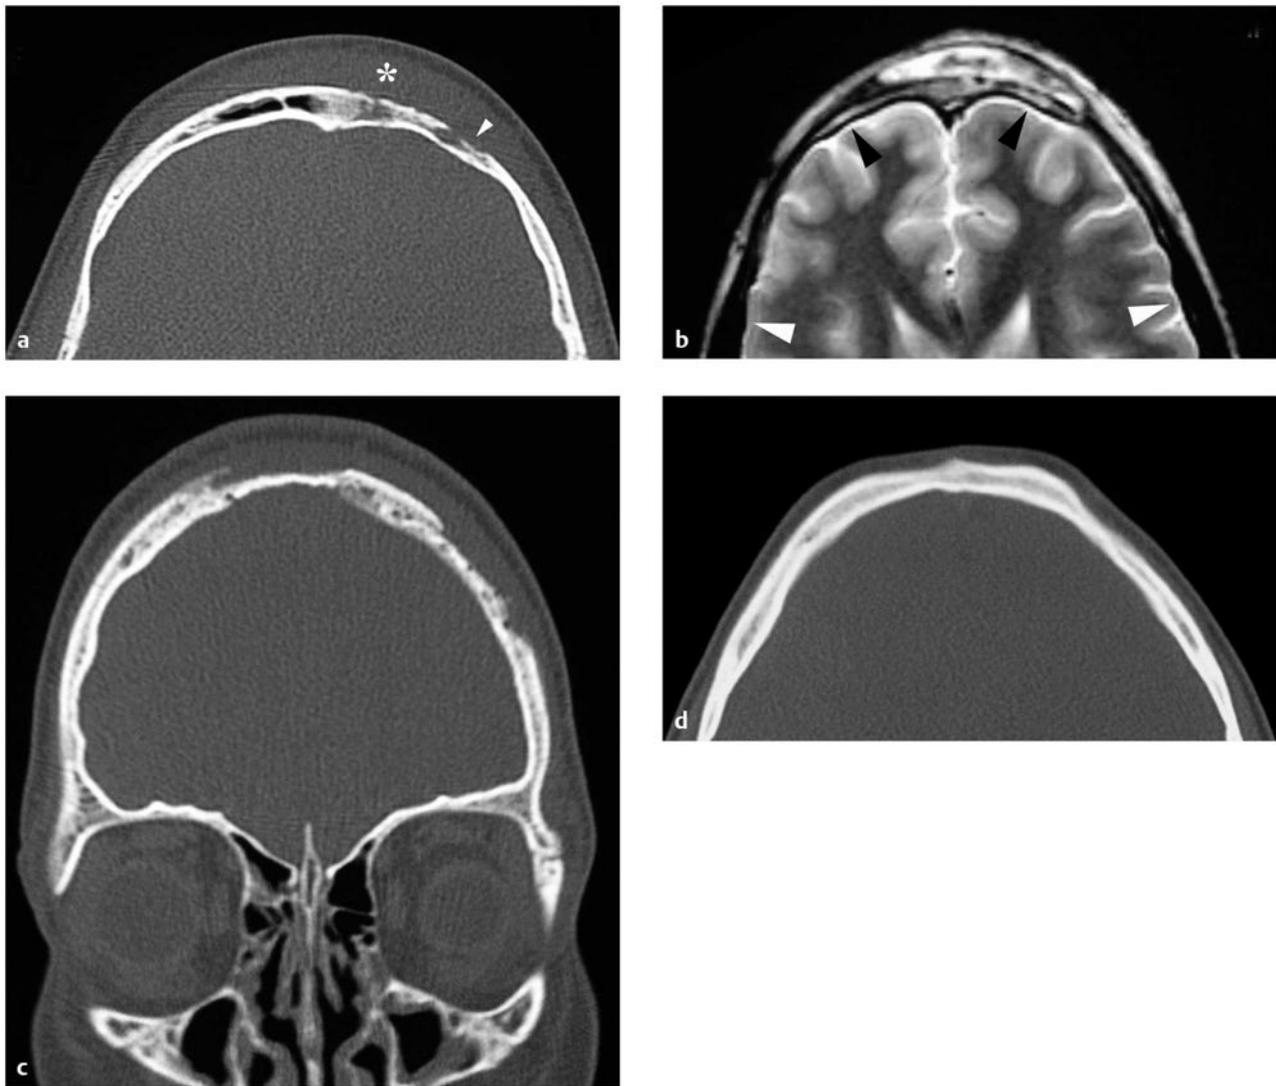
(a) A male teenager came to attention with headache, fever, and extensive swelling of his forehead and scalp. This computed tomographic (CT) scan performed early in his course shows a large subperiosteal abscess (*white asterisk*) and osteomyelitis of the frontal bone with extensive erosive changes (*white arrowhead*). (b) This axial, T2-weighted MR imaging sequence shows high signal intensity, reflecting marrow edema in the involved frontal bone (*black arrowheads*), in comparison with the relatively uninvolved parietal bones (*white arrowheads*). There was no epidural abscess in this case. (c) Despite sinus drainage and parenteral antibiotics, the progress of the osteomyelitis was not arrested immediately. This coronal CT scan performed in the second week of treatment shows worsening erosion of the frontal bone. Extensive débridement of the frontal bone was considered, but it was deferred. (d) After 6 weeks of parenteral antibiotic therapy, the frontal bone healed. (Courtesy of Drs. Joseph Piatt, Jennifer Smith, and Eric Faerber.)
